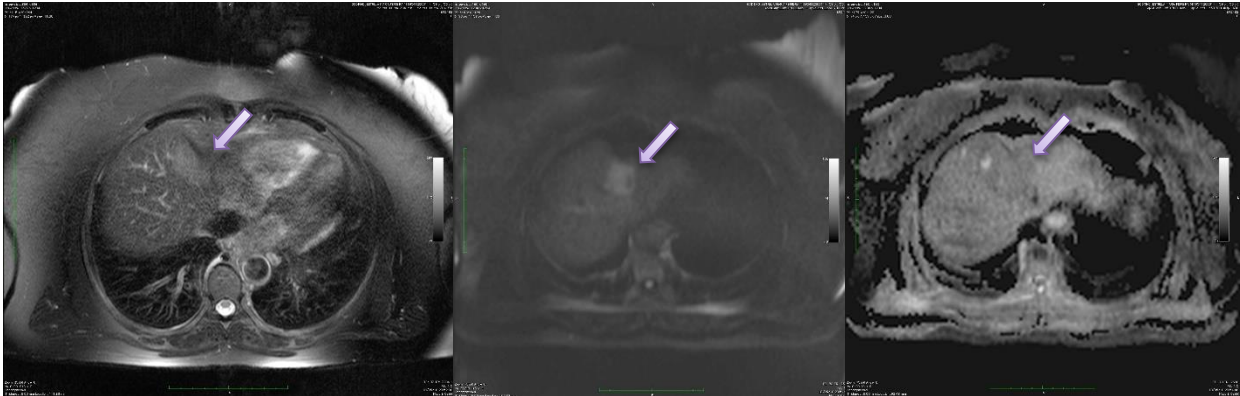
Diffusion-weighted MRI in a liver with a Steatotic HCA: (A) Fat-suppressed T2-weighted fast spin echo image shows a HCA located in the IV segment that is hyperintense to the liver; (B) in DW MRI with $b = 700 \text{ sec/mm}^2$, the lesion shows slight hyperintensity compared with the background liver; (C) in the ADC map, the lesion has similar signal to the one presented in the liver.
